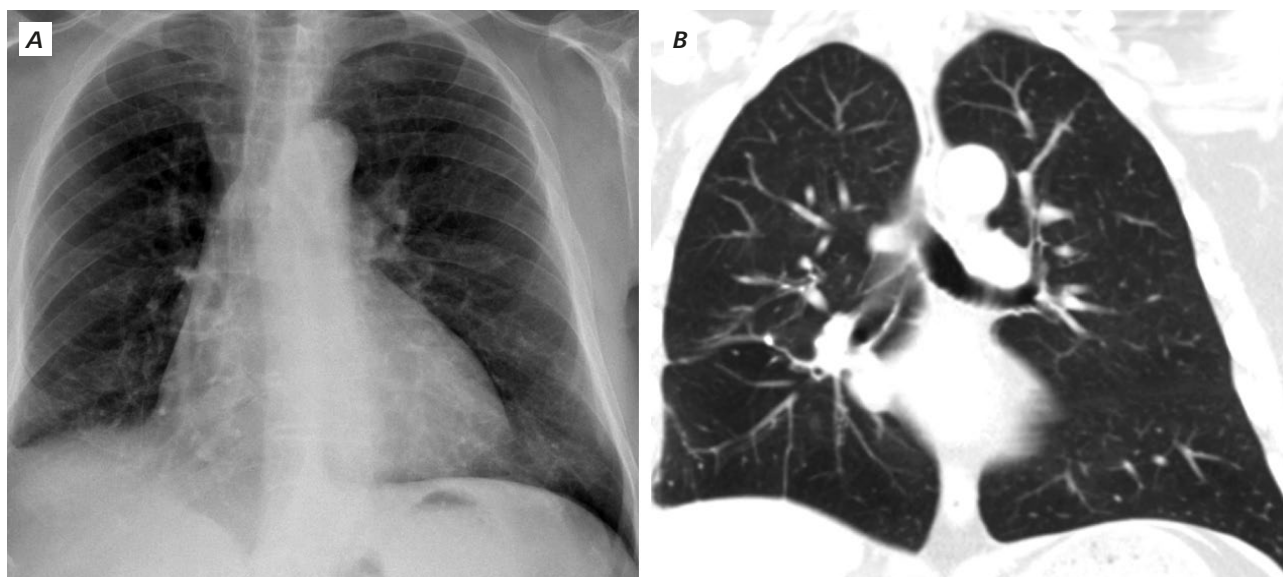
A - Chest X-ray at discharge and B - Chest CT scan at 6-month postop with no signs of disease recurrence.
